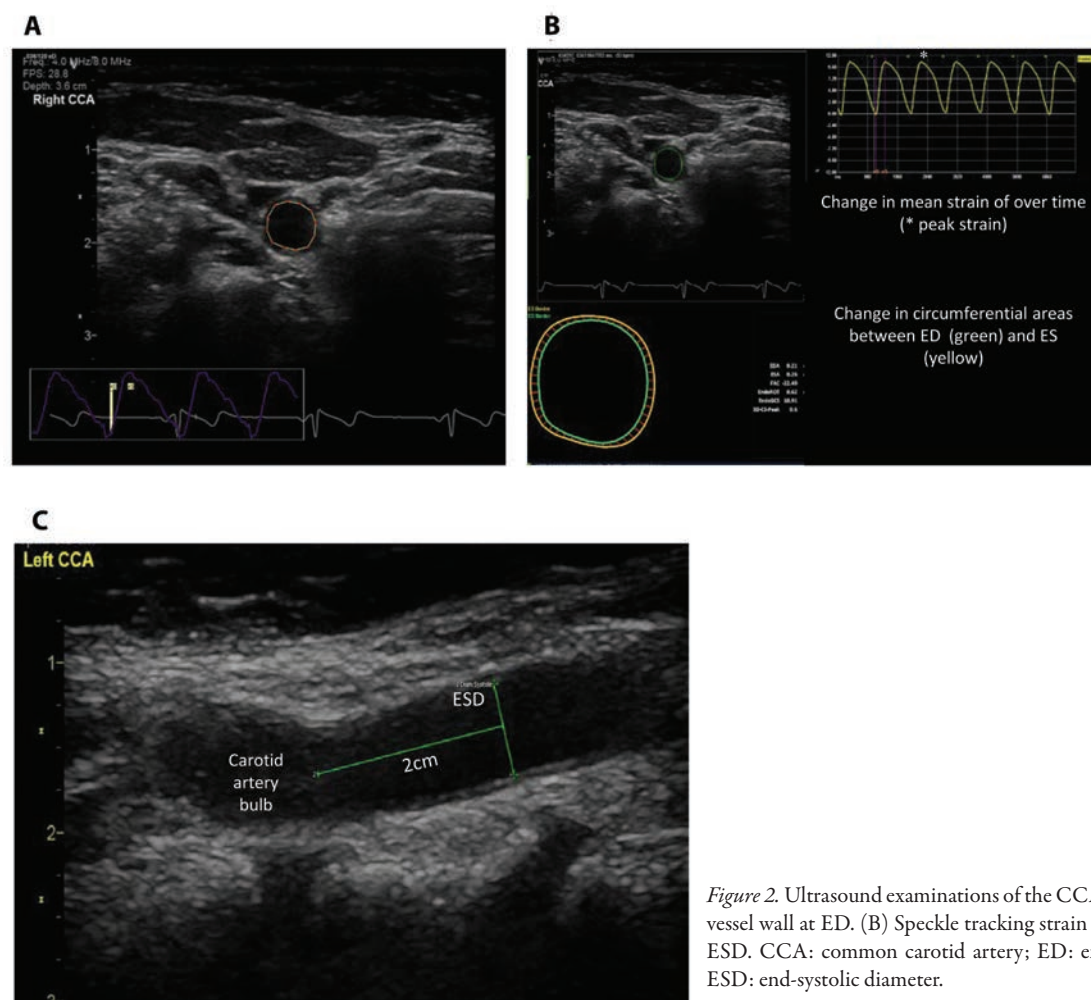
Ultrasound examinations of the CCA. (A) Outline of the internal vessel wall at ED. (B) Speckle tracking strain output. (C) Measurement of ESD. CCA: common carotid artery; ED: end-diastole; ES: end-systole; ESD: end-systolic diameter.
